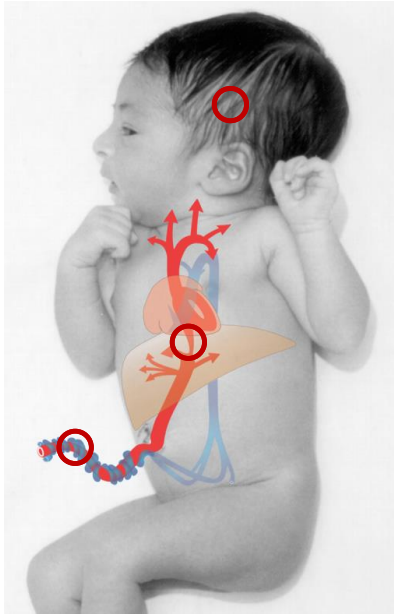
Demonstration of central fetal circulation (reproduced by permission (150)). The most common vessels being examined by Doppler are the umbilical artery, Ductus venosus and middle cerebral artery; sites are marked by red circles.
